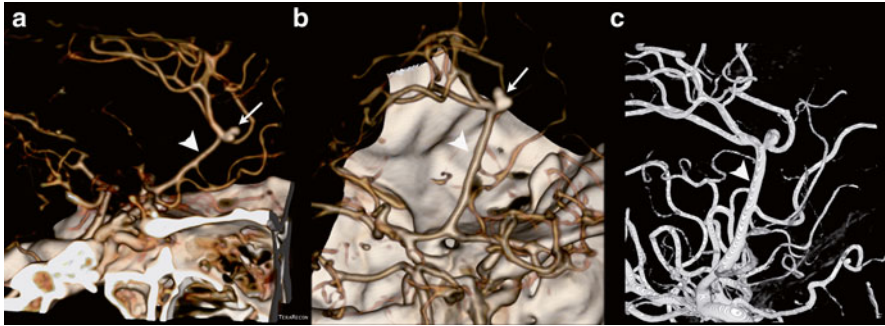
A 50 y/o male presented with a subarachnoid hemorrhage, due to a pericallosal aneurysm (*arrow*). As coincidental normal variant an azygos configuration of the anterior cerebral artery was present. The pericallosal aneurysm was treated by surgical clipping. Lateral (a) and superior oblique (b) view of volume-rendered CTA demonstrates the azygos configuration (*arrowheads*). The *arrow* points to the bilobar pericallosal aneurysm. These findings were confirmed at DSA (c)
